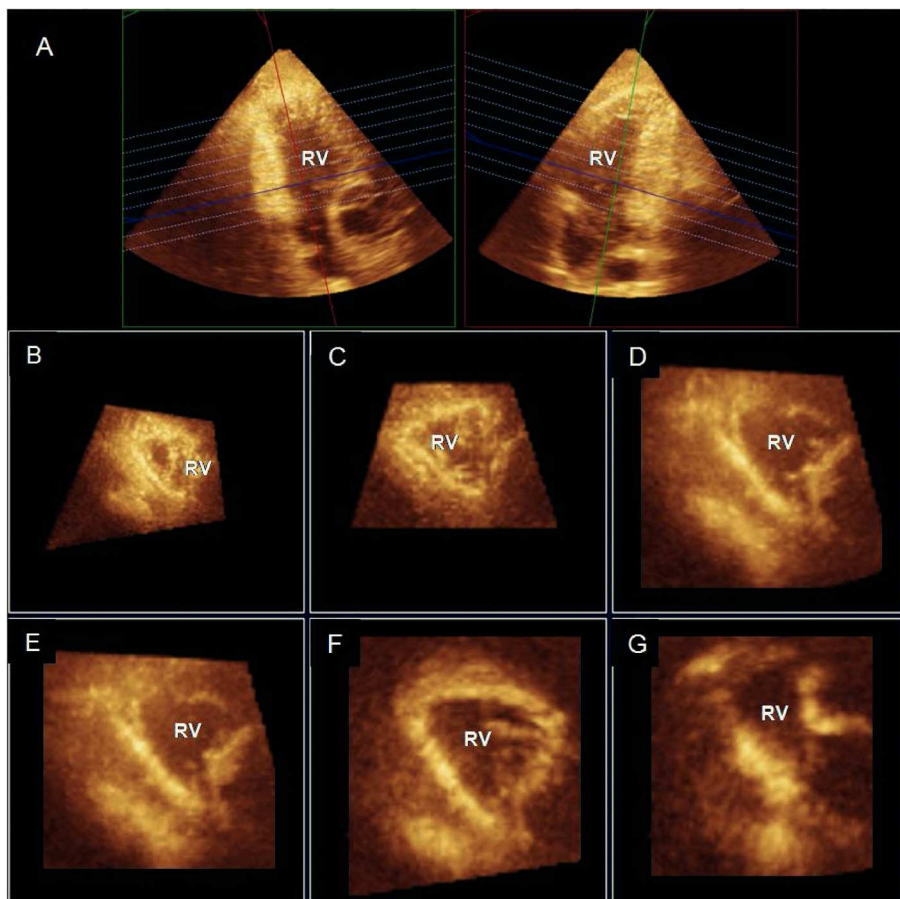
Real-time 3D echocardiogram (Full volume mode acquisition) of the right ventricle (RV) reformatted into coronal (A, right), sagittal (A, left), and multiple short-axis views showing segmental geometry of the RV (B, C: apex; D, E: mid; and F, G: basal segments).
